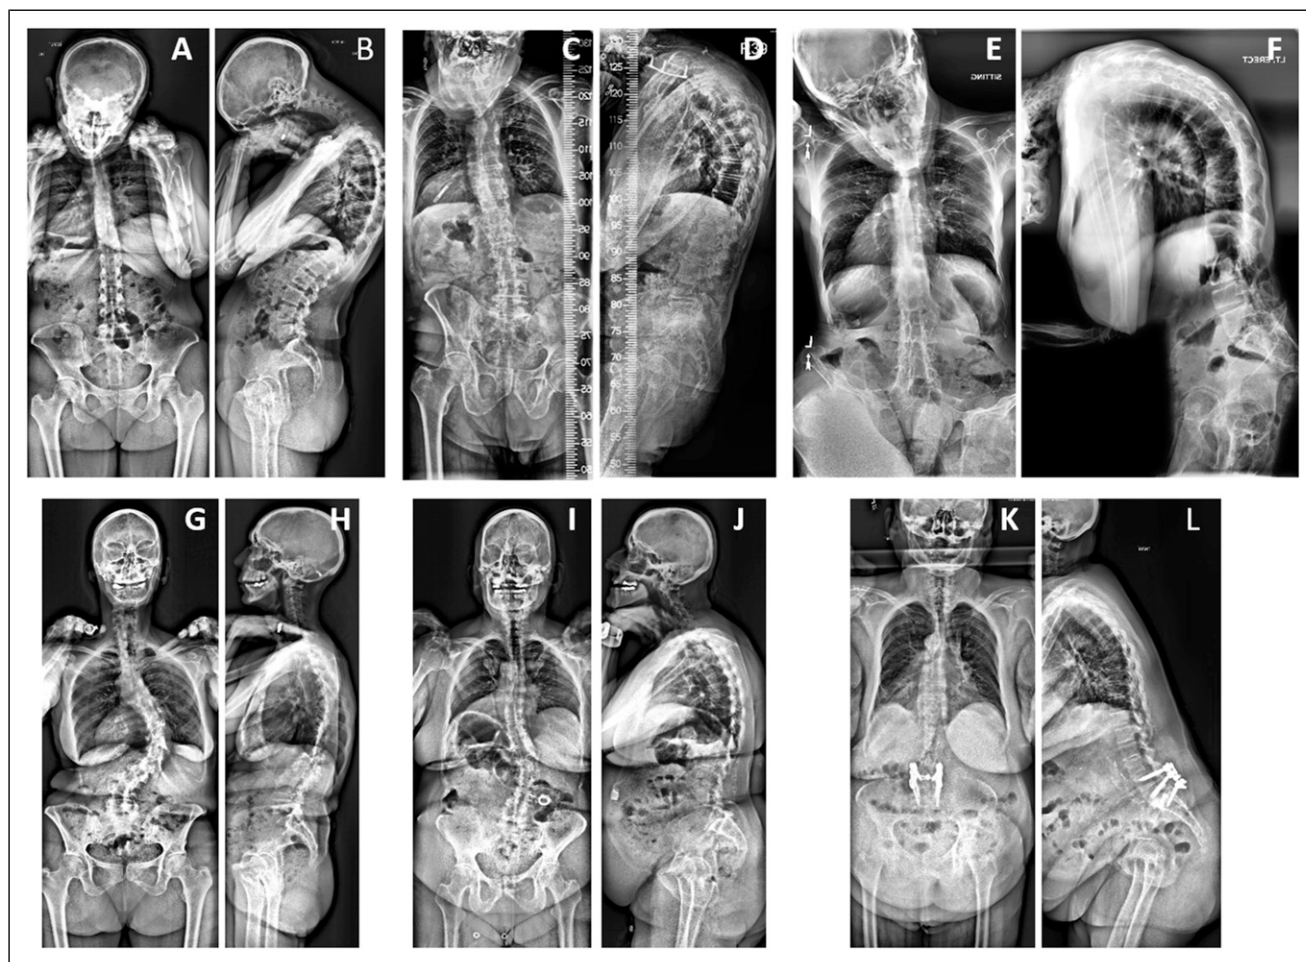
Postero-anterior (PA, left) and lateral (right) radiographs of representative adult cervical deformity (A-F) and adult thoracolumbar deformity (G-L) patients with a range of frailty severities. A and B: 37-year-old woman with dropped head syndrome and “no frailty” based on Edmonton Frail Scale [EFS] score of 3 and Canadian Study on Health & Aging Clinical Frailty Scale (CFS) score of 3 (“managing well”). C and D: 82-year-old man with degenerative cervical kyphosis and “vulnerable” to frailty based on EFS score of 7 and CFS score of 3 (“managing well”). E and F: 35-year-old man with ankylosing spondylitis and “moderate frailty” based on EFS score of 11 and CFS score of 6 (“moderately frail”). G and H: 64-year-old woman with degenerative thoracolumbar scoliosis and “no frailty” based on EFS score of 3 and CFS score of 3 (“managing well”). I and J: 58-year-old woman degenerative thoracolumbar scoliosis and “vulnerable” to frailty based on EFS score of 6 and CFS score of 3 (“managing well”). K and L: 66-year-old woman with iatrogenic flatback and positive sagittal malalignment and “moderate frailty” based on EFS score of 10 and CFS score of 5 (“mildly frail”).
